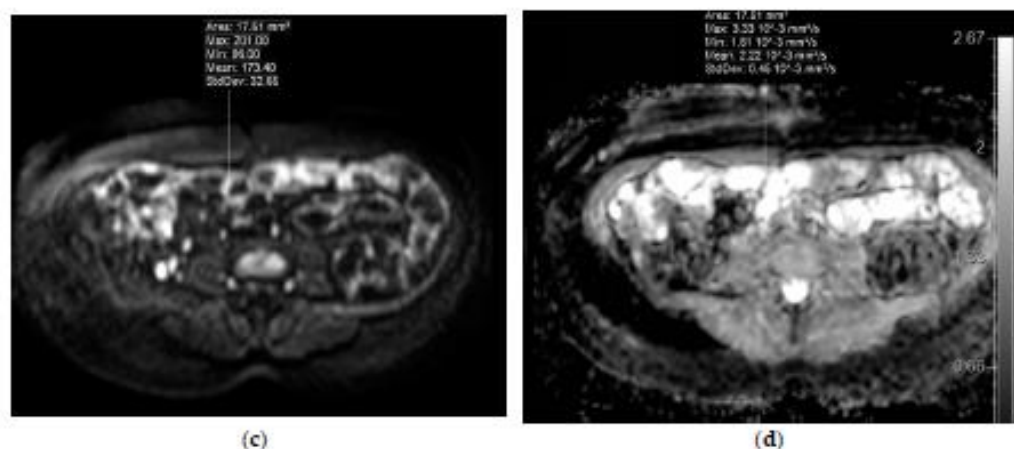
MRE of a 53-year-old female patient with dyspeptic complaints, with no morphologically verified IBD. Selecting regions of interest (ROIs) for apparent diffusion coefficient (ADC) measurements in DWI images of collapsed (a) and distended (c) jejunum showing high SI in the DWI tracking images of $b = 800$ s/mm². ADC values appear on the ADC map (b, for collapsed jejunum, d, for distended jejunum).
